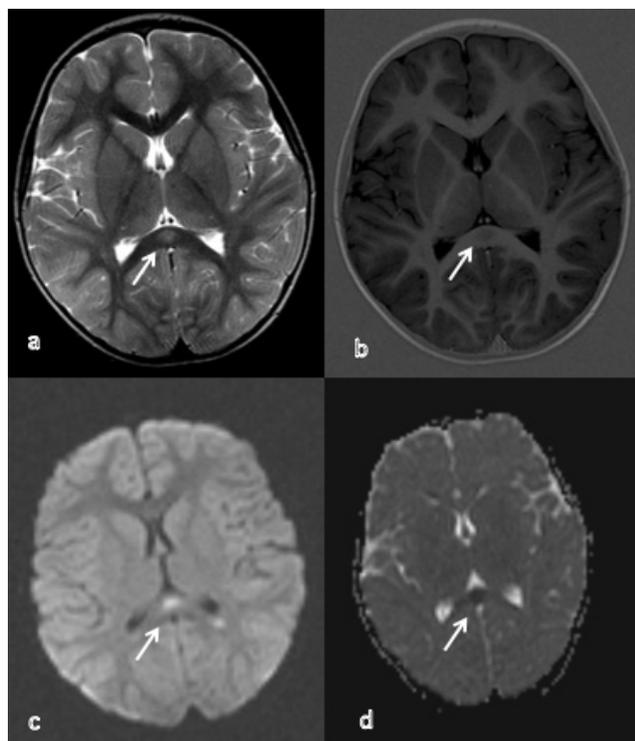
Cranial magnetic resonance images on admission demonstrating a splenial lesion of the corpus callosum. Axial T1-weighted (a), axial T2-weighted (b), diffusion-weighted (c), and the corresponding apparent diffusion coefficient map (d)
